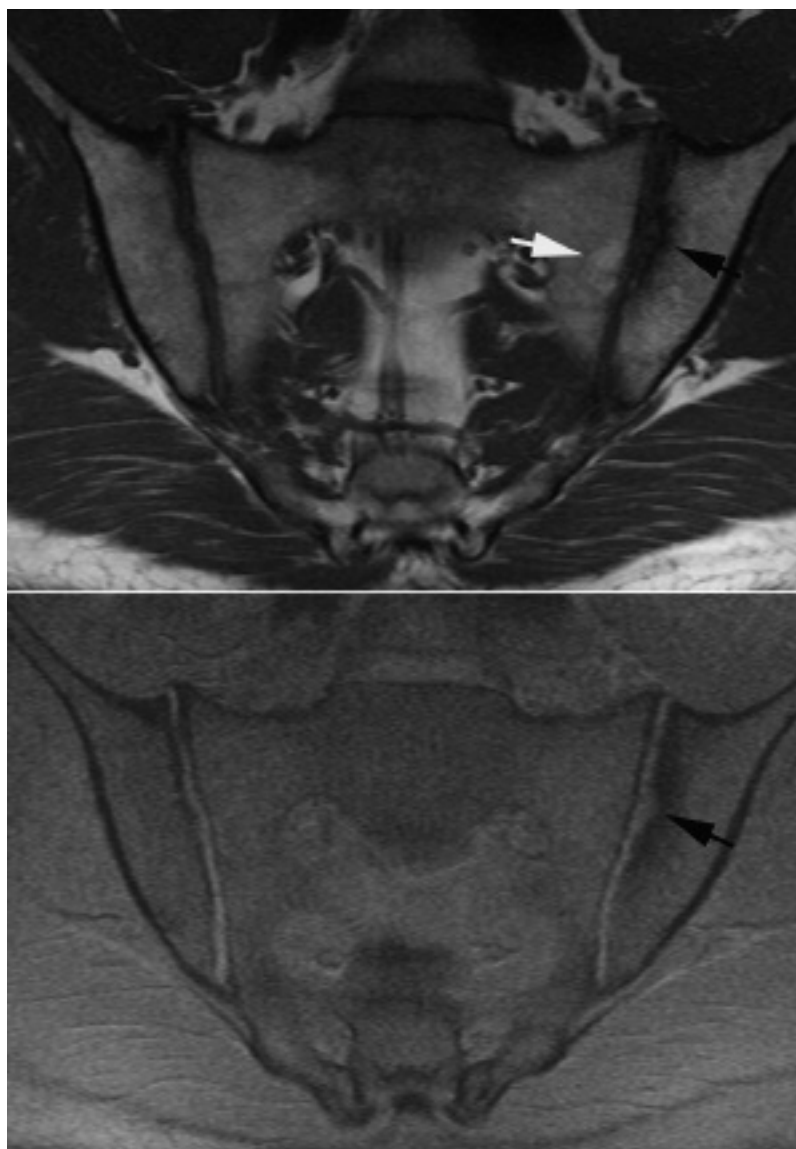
Primary magnetic resonance imaging, semicoronal T1 (upper image) and T1 fat-saturated images showing slight chronic changes in the form of left-sided erosion (black arrow) of the iliac joint facet and slight subchondral fatty marrow deposition in the sacrum (white arrow). There were no signs of disease activity at this time.
